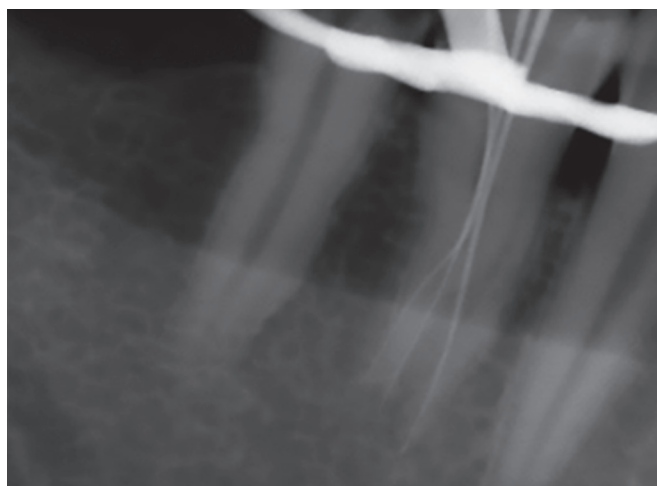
Working length radiograph of tooth #44 showing three canals
